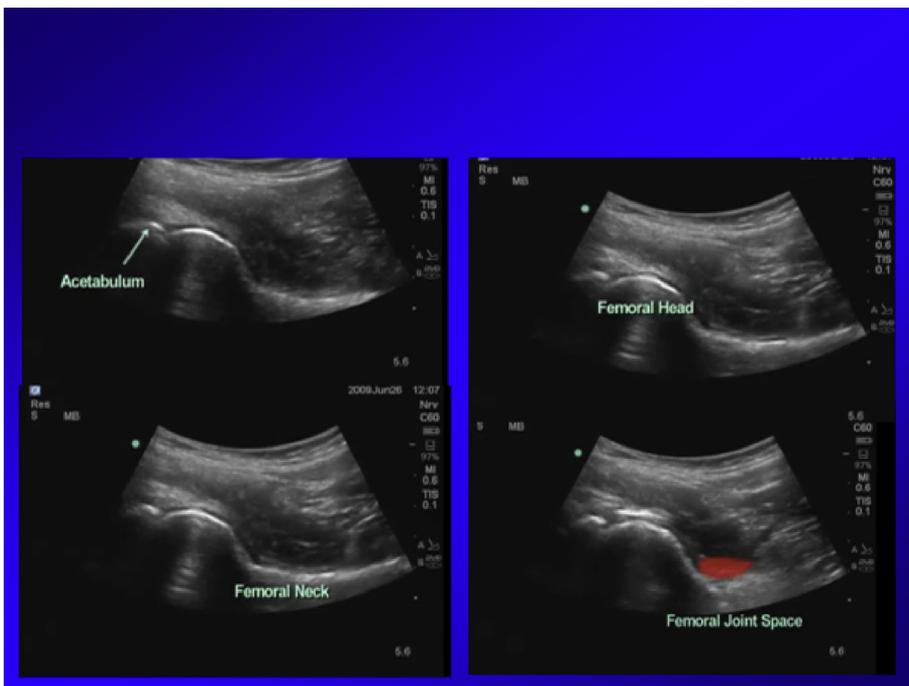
Ultrasound-guided hip injections.
